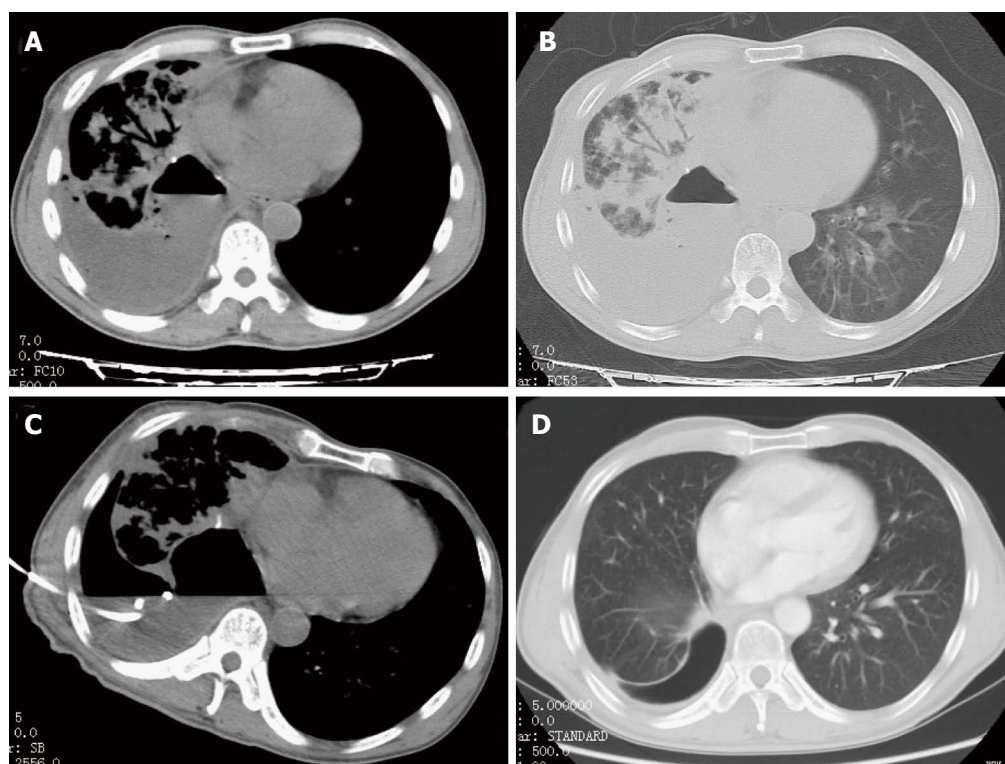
A 36-year-old male presented with fever and chest pain after right lung cancer resection. A and B: Unenhanced transverse CT shows empyema in right pleura with liquid-gas plane, and infections can be seen in right lung; C: Catheter was placed under CT-guidance; D: Empyema and infections were absorbed after 2 mo.
